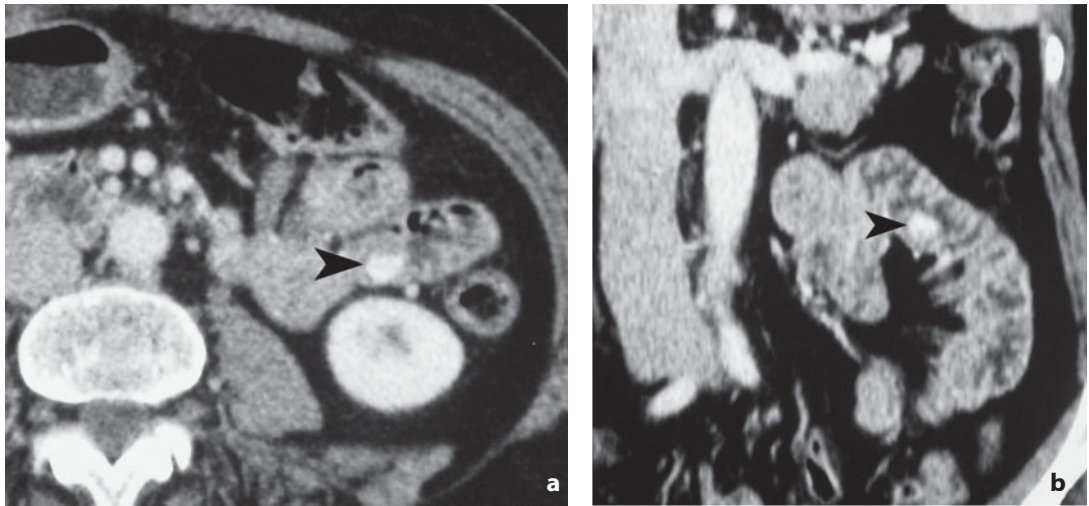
Computed tomography. Intestinal metastasis following right nephrectomy. Patient with melena. The axial image (a) and coronal reconstruction (b) of the arterial phase of the dynamic study show a hypervascular lesion (*arrowhead*) at the level of the first jejunal loop
